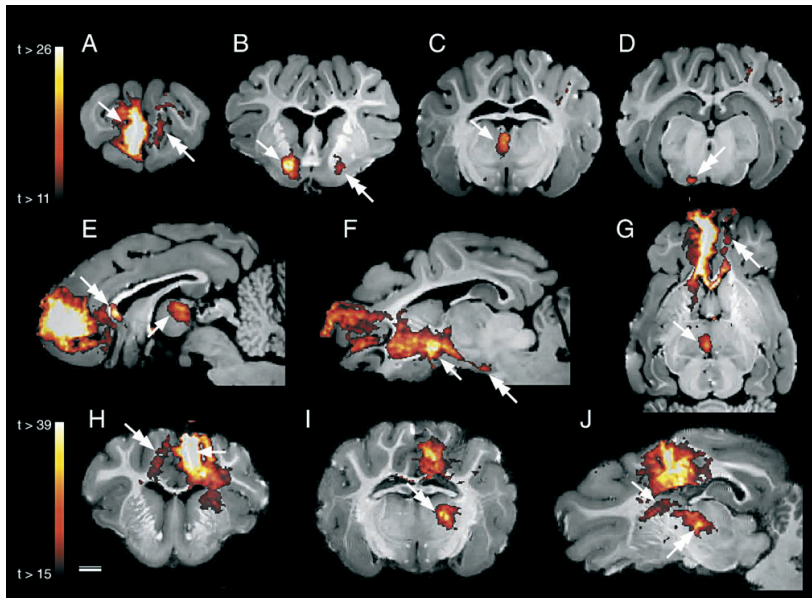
In vivo tracing using manganese injected into the right PFC of brain 2 (A–G) and the left MC of brain 3 (H–J). Pathways of the manganese labeling are represented by the statistical *t*-maps (color bar) visualized on the high resolution in vitro MPRAGE MRI seen in coronal (A–D, H, I), sagittal (E, F, J) or horizontal section plane (G). The right side of the brain is depicted in the left side of the figures. Injections into the PFC (A, arrow) revealed a corticocortical pathway to the contralateral PFC (A, G, double arrow) crossing through the rostrum of the corpus callosum (E, double arrow). Ipsilateral labeling of manganese was observed passing through the internal capsule depositing ventrally in a high intensity ventral area (B, F, arrow) as well as contralaterally (B, double arrow). More caudally, this region splits into at least two distinct pathways; one passes through the ventral thalamus eventually entering the MD nucleus (C, E, G, arrow), while another pathway is directed ventrally towards the SN (D, F, double arrow). Manganese injected into the MC (H, arrow) projects to the contralateral MC (H, double arrow) via the body of corpus callosum, as well as to the caudate (J, arrow) and the VA and VL nuclei of the thalamus (I, J, double arrow). Scale bar = 5 mm.
